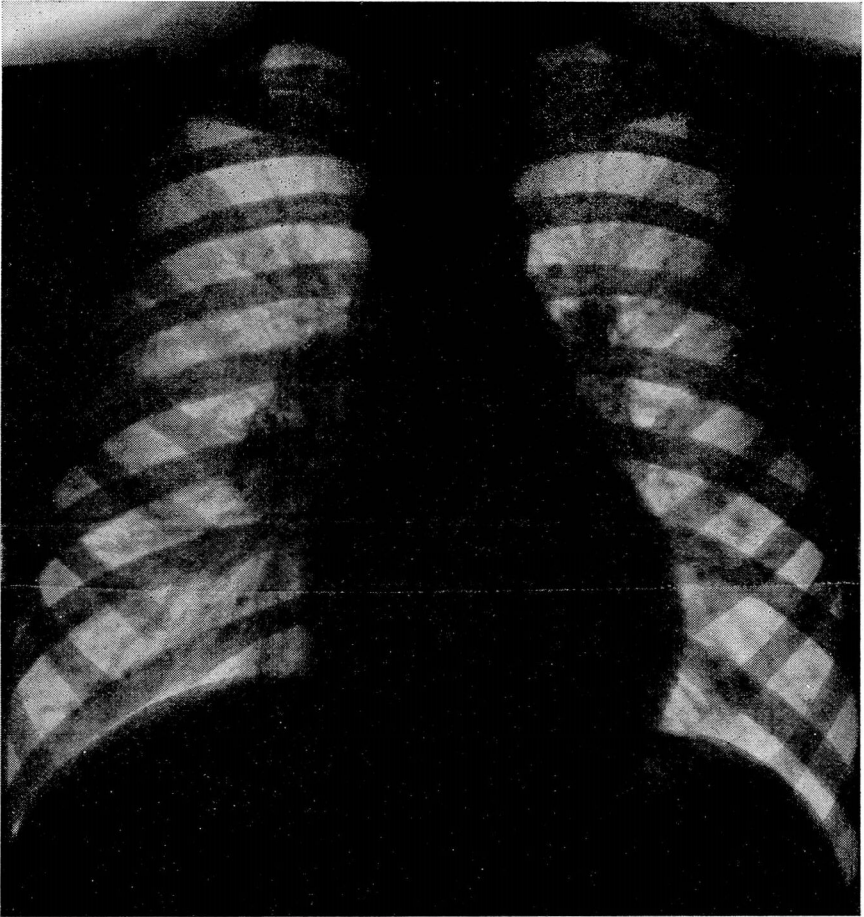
CASE 2: Calcification of tuberculous tracheobronchial lymph nodes in the same patient after roentgen ray treatment. The condition is arrested or healed six years later.
